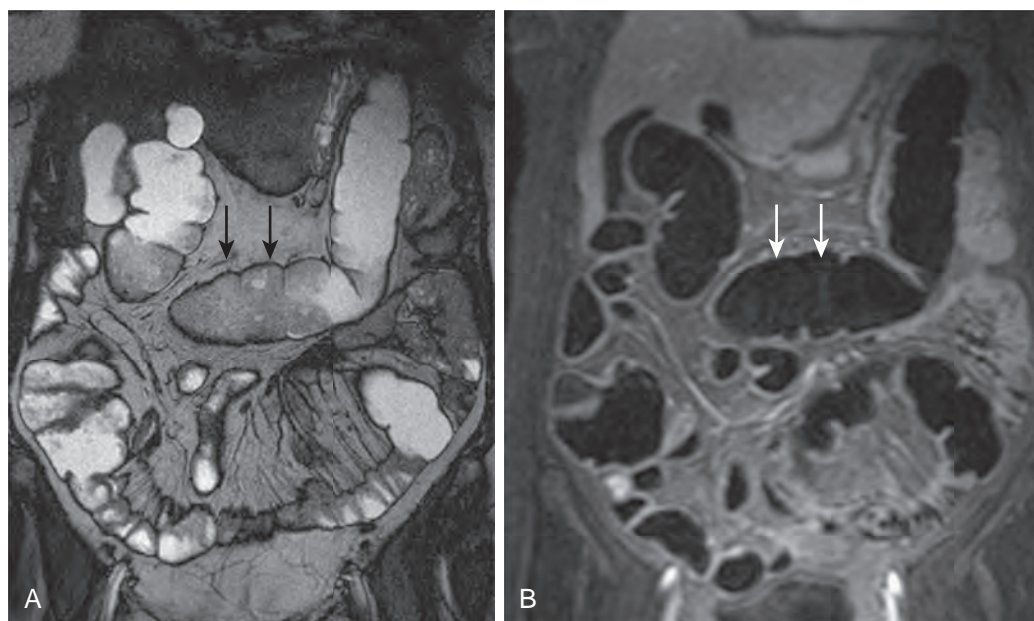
Fecal material visibility with tagging. A. Note that on the true FISP image the fecal material presents with moderate signal intensity (arrows). B. Fecal material (arrows) may be rendered almost invisible on T1-weighted images by means of fecal tagging.
